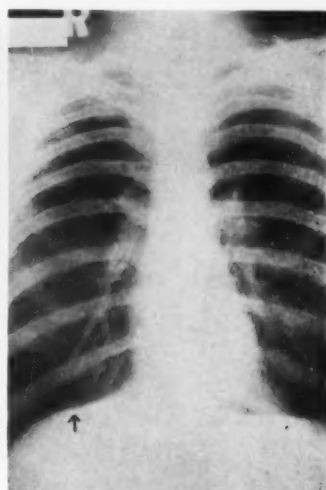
Chest x-ray, September, 1952, showing non-calcified rounded peripheral density near right diaphragm.
